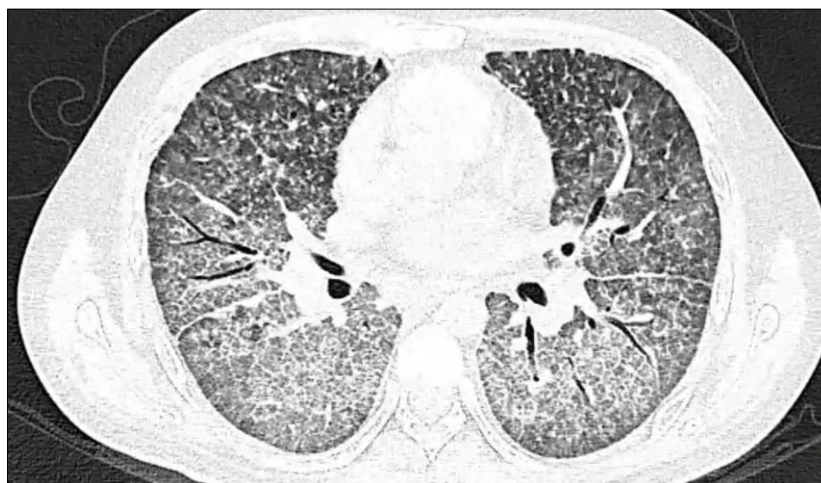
Axial chest CT, lung window: bilateral ground-glass opacities with superimposed interlobular septal thickening (“crazy paving”) and peribronchial thickening
